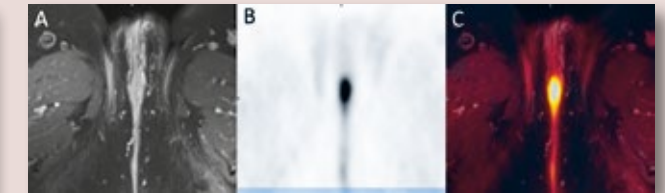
^{18}F -FDG PET/MRI images from a project investigating the diagnostic value of PET/MRI in patients with newly diagnosed vulvar cancer, with special focus on localized spread of the tumour. A) Transverse contrast enhanced T1-weighted fat-suppressed Turbo spin echo MRI. B) FDG PET. C) PET/MRI fused image.
